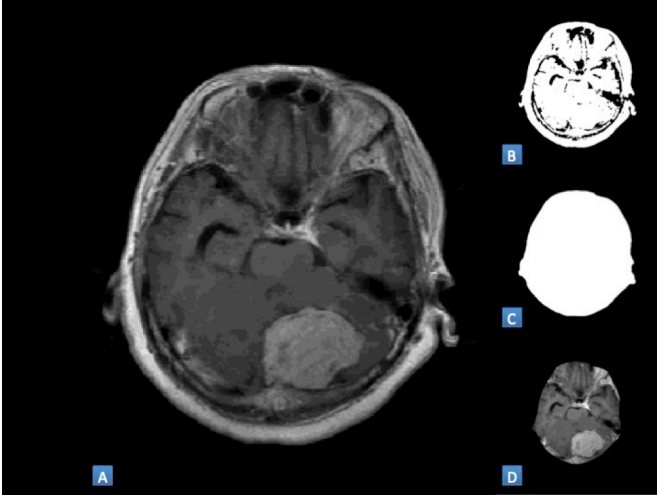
(A) Typical MRI Image of brain (B) Binarized image showing all structures identified (C) Mask created from all structures (D) Skull-stripped MRI image. An eroded mask from C was applied to A. Contrast-enhancement is performed on this before applying the FCM algorithm
